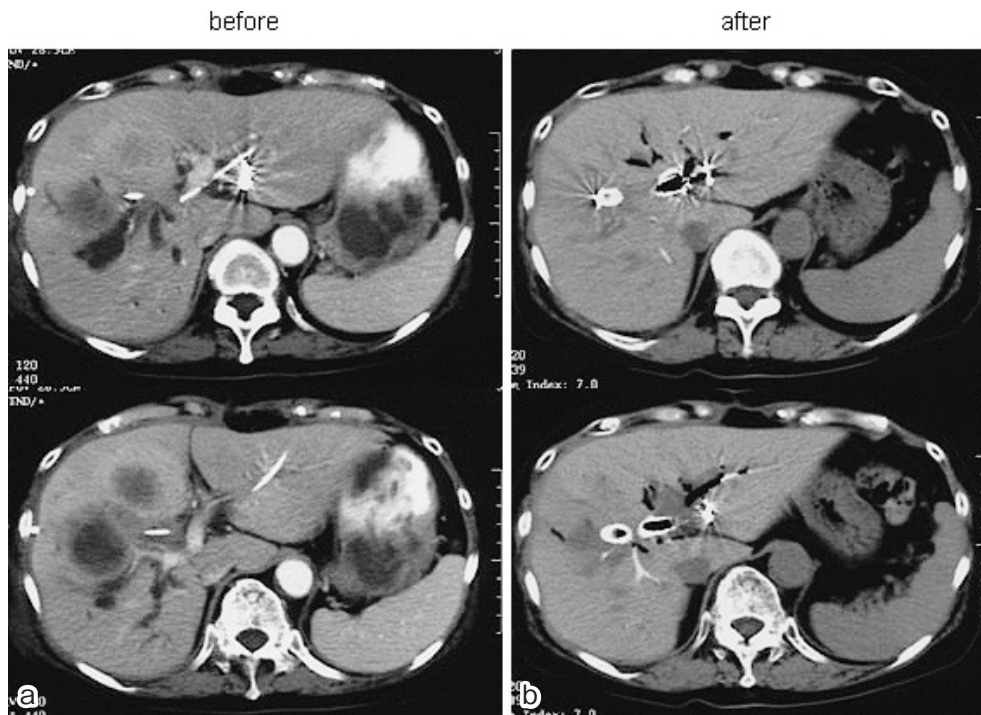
Abdominal computed tomography showing tumors before (a) and after (b) chemotherapy. a) Tumors have invaded the right and middle lobes of the liver. b) Lesions have decreased in size.
